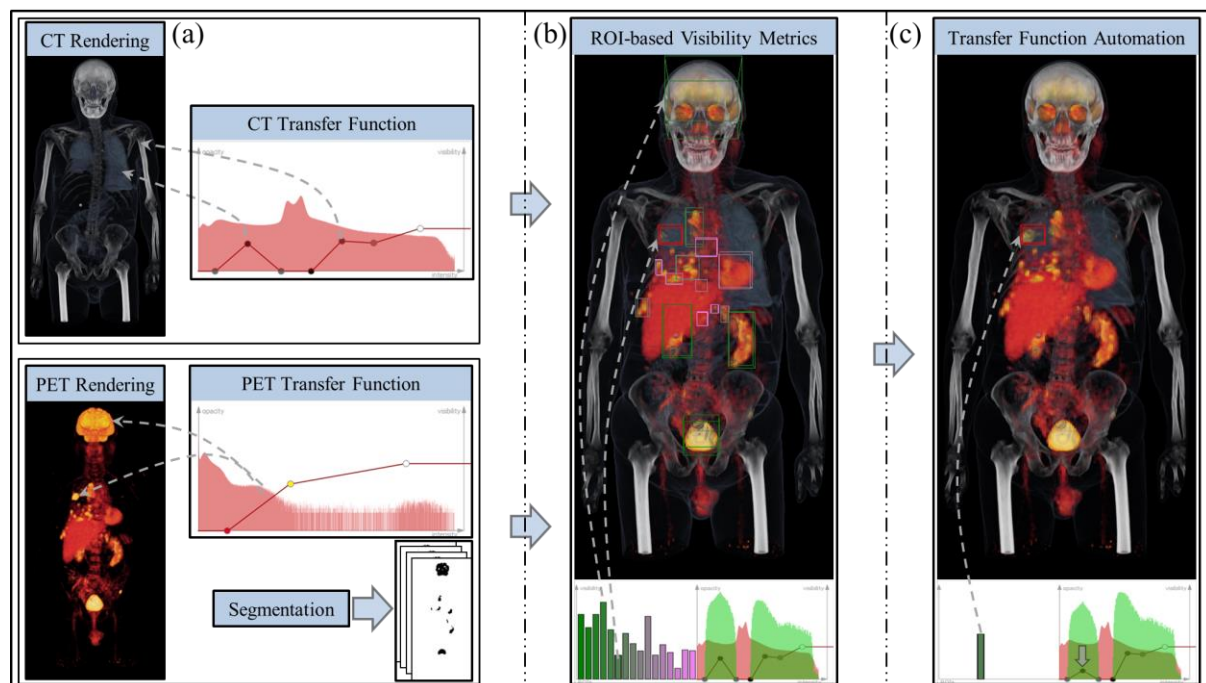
Overview of multi-modality PET-CT visualisation framework with our m^2 -vtf.
